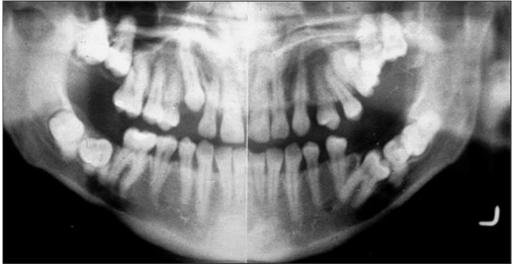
Panoramic radiograph of multiple impacted teeth with differing orientations. Note the kissing molars, mandibular left first molar tooth #19 in a horizontal distoangular position with the second molar tooth #18 trapped between the third molar tooth #17 in a horizontal mesioangular position.
